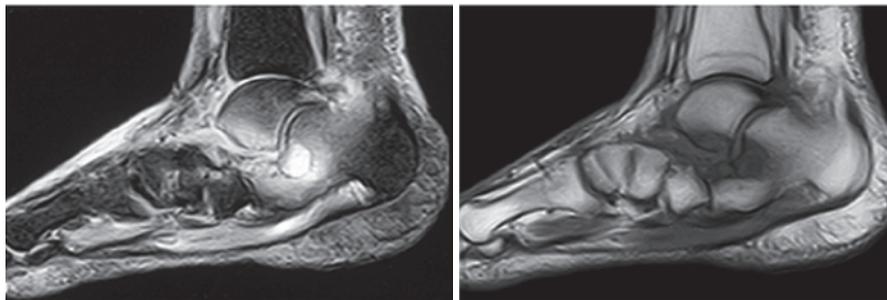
The MRI appearance of Charcot foot in the acute phase, with inflammation of the bone marrow and soft tissue being apparent as enhancement on the left (T2-weighted) image, and as suppression on the right image
